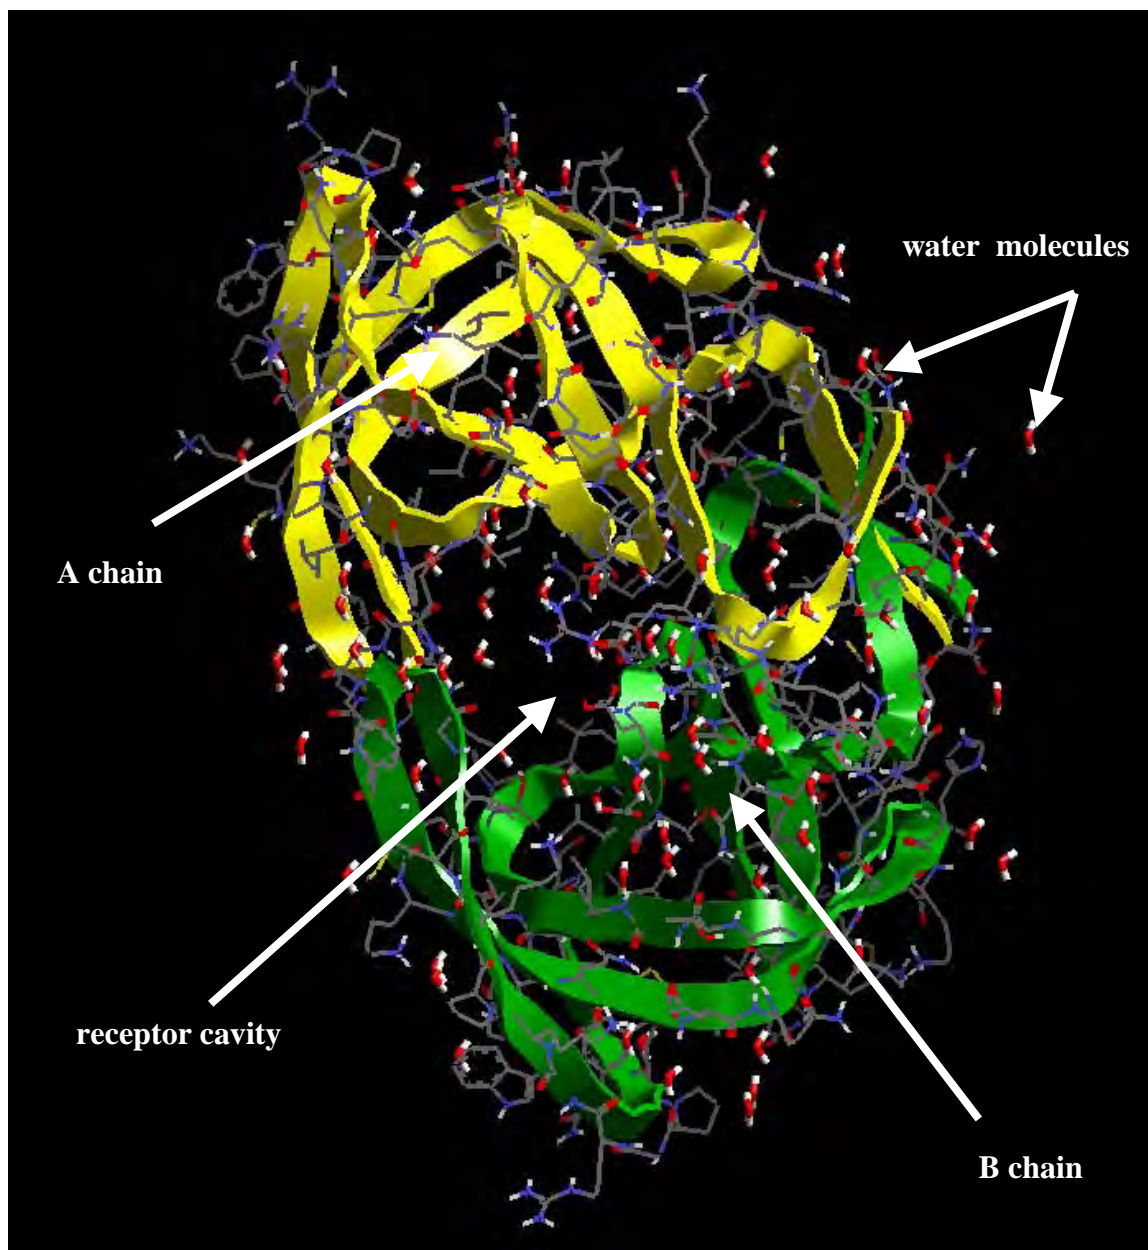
Active Site of the HIV-I protease enzyme from the X-ray structure reported by Kempf *et al.*²⁰⁴
